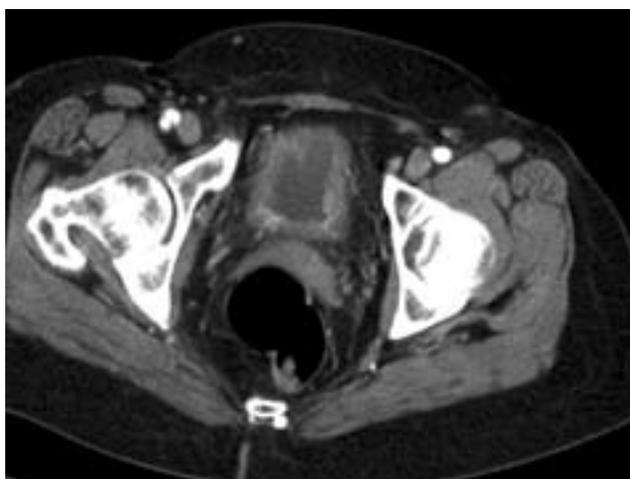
CT demonstrates diffuse irregular bladder wall thickening found to represent transitional cell carcinoma.
